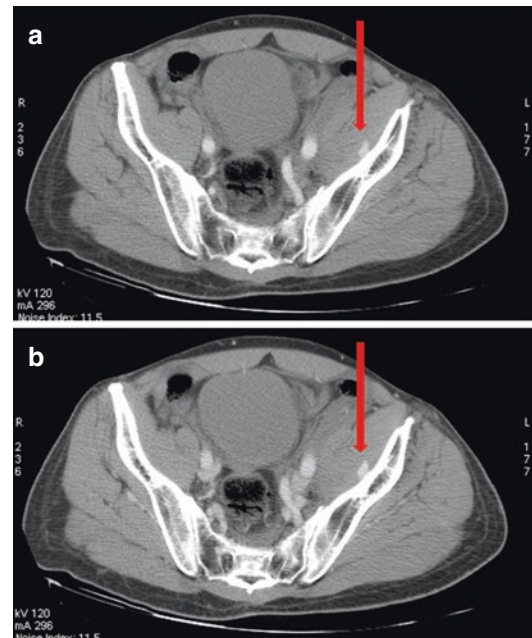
Pseudoaneurysm on axial CT image on arterial (a) and venous (b) phases. A focal well-circumscribed arterial outpouching of contrast-enhanced blood is seen inside left iliac muscle (arrow) in the arterial phase (a). On portal venous phase (b), the area does not enlarge and it reflects the attenuation value of the blood pool
